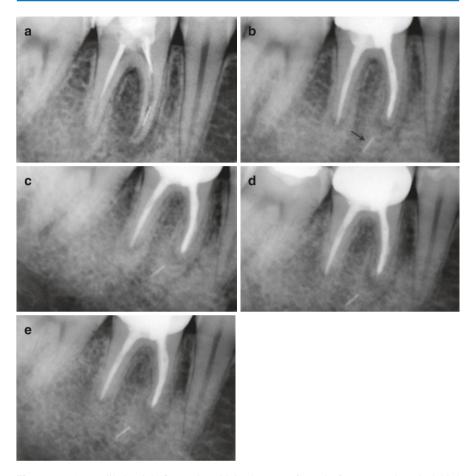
(a) Mandibular right first molar with inadequate RCT and a fragment at the apical third of the mesiobuccal canal. (b) Immediate post-obturation radiograph. Note the inadvertent extrusion of the fragment to the periapical tissues (*arrow*) during retrieval efforts with the file bypass technique. (c-e) Recall radiographs at 4, 9, and 12 years revealed healthy periapical tissues (Courtesy of Prof. P. Beltes)
